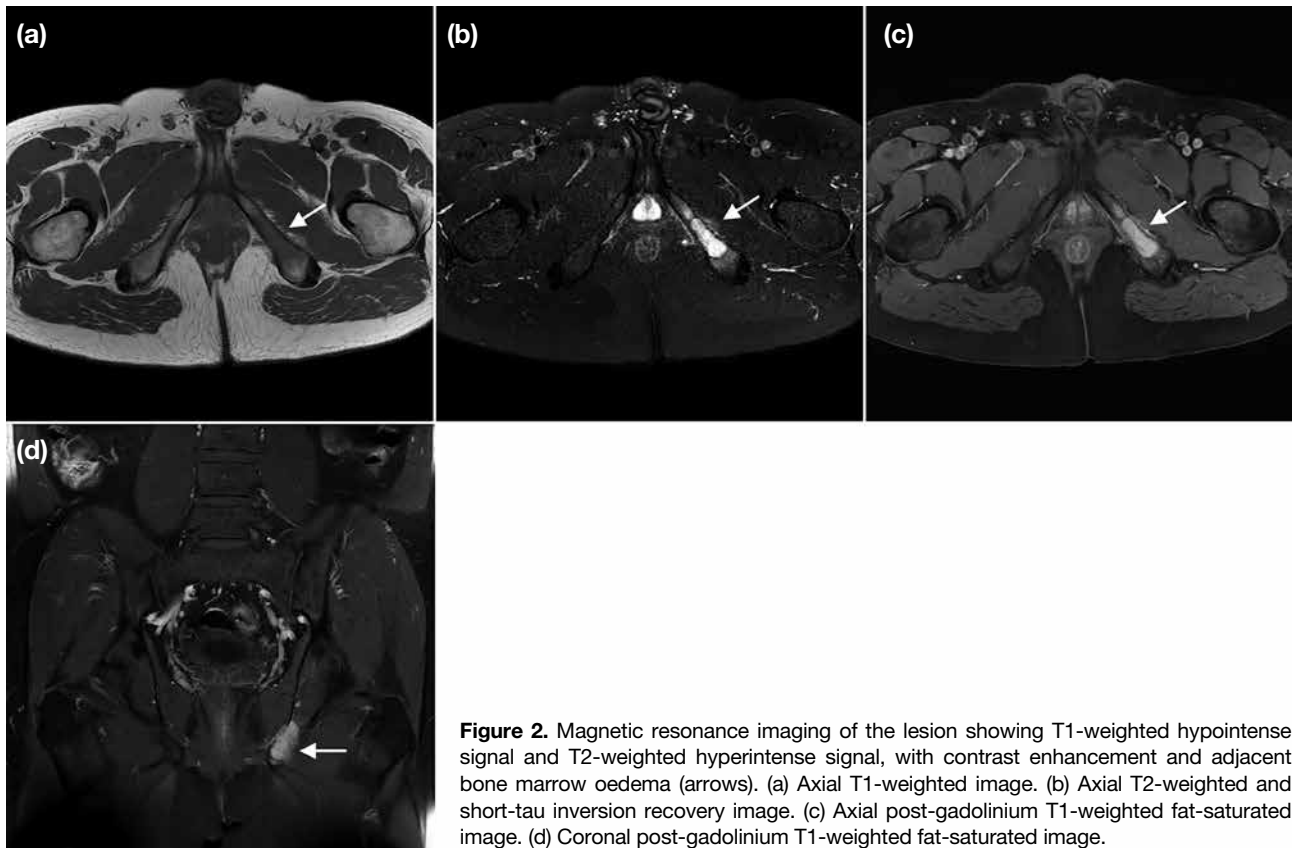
Magnetic resonance imaging of the lesion showing T1-weighted hypointense signal and T2-weighted hyperintense signal, with contrast enhancement and adjacent bone marrow oedema (arrows). (a) Axial T1-weighted image. (b) Axial T2-weighted and short-tau inversion recovery image. (c) Axial post-gadolinium T1-weighted fat-saturated image. (d) Coronal post-gadolinium T1-weighted fat-saturated image.
